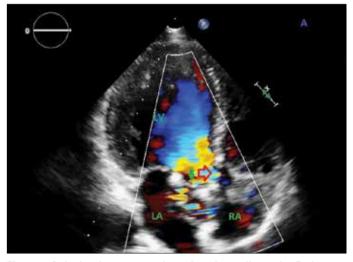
Apical 5 view on transthoracic echocardiography. Red arrow showed aortic flow through the aortic valve. Green arrow showed the flow through the pseudoaneurysm LA - left atrium; LV - left ventricle; RA - right atrium
